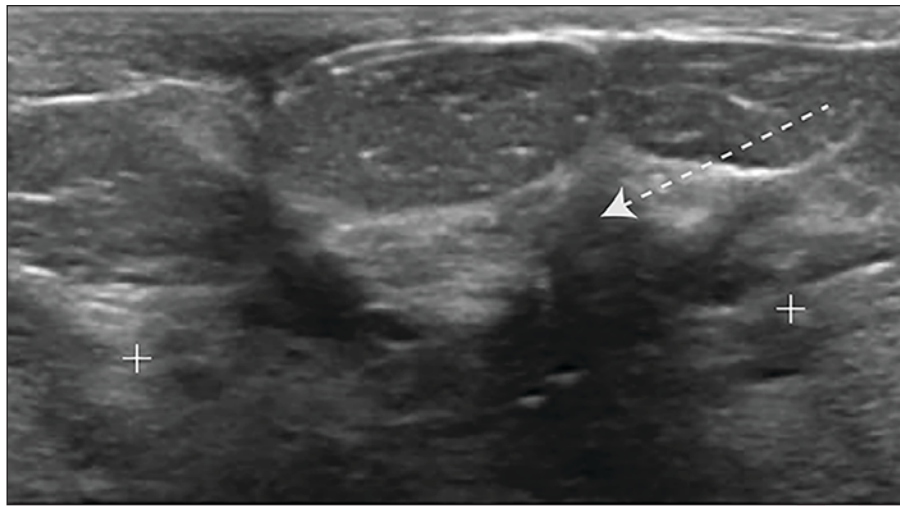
Cross-modality BI-RADS v2025 descriptors for nonmass lesions in 67-year-old patient. Ultrasound image performed for evaluation of palpable finding (A) shows heterogeneous nonmass lesion (dashed arrows) with posterior acoustic shadowing. Cranio-caudal (B) and mediolateral oblique (C) recombined contrast-enhanced mammography (CEM) images show segmental enhancement (dashed arrows) involving nipple–areolar complex. Standardized terminology facilitates correlation of nonmass lesion on ultrasound with enhancement findings on CEM when available.
